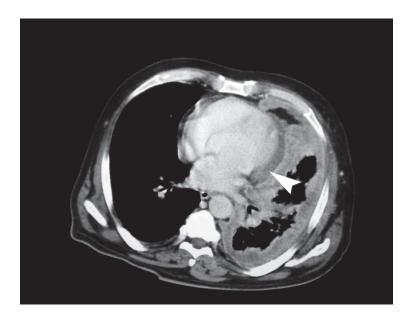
Axial contrast enhanced CT shows pericardial invasion and pericardial effusion.
